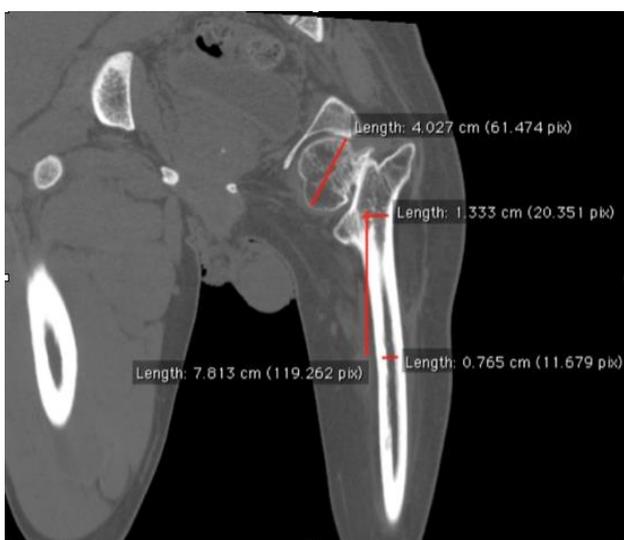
Coronal section of the CT scan showing the neck of femur non-union and the stenotic proximal femur.
